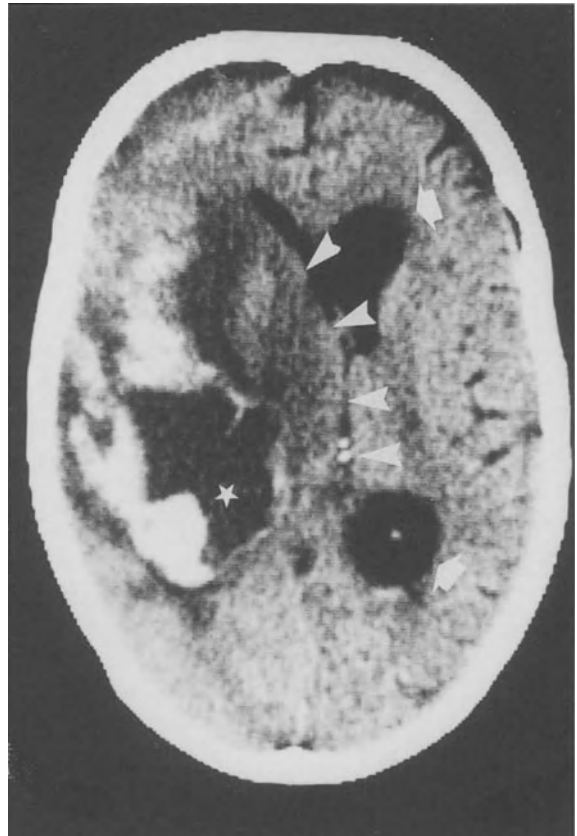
CT appearance of a subacute, massive intracranial hemorrhage that occurred during the terminal stage of an AIDS patient with pancytopenia. The examination was performed 6 days after the worsening of the patient's condition. The hemorrhage is depicted as an inhomogeneous, hyperdense area, surrounding a hypodense mass (*asterisk*). There is considerable midline shift (*arrowheads*) and enlargement of the contralateral ventricle (*arrows*) due to disturbed CSF circulation. At autopsy, the hypodense mass proved to be a collection of a semiliquid, plasmalike substance
